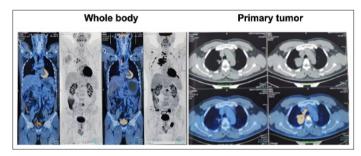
Comparison between PET-CT images before and 13 weeks after ICI therapy with a single dose of anti-PD 1 antibody. The left side shows the whole body image comparison. The initial PET images are on two the right-hand side panels, while the after treatment PET images are next to the left. The regression of primary tumor is presented on the right side as labeled. Again, the before treatment images are on the two right-side panels and the after images are on the left.
